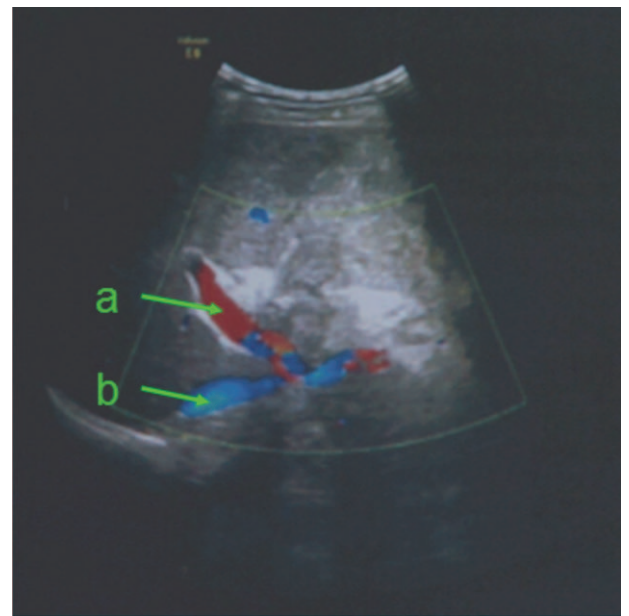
One month after operation, color Doppler ultrasound shows no marked signal of blood stream in proper hepatic artery. a: portal vein, b: inferior vena cava.
